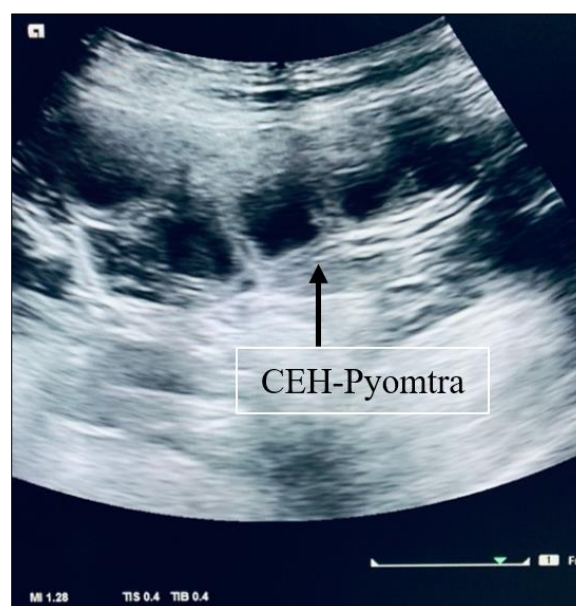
Ultrasonogram of CEH-Pyometra complex. Figure showed endometrial proliferation along with formation of anechoic pockets in abdomen (approx. 4 cm diameter uterine lumen)
